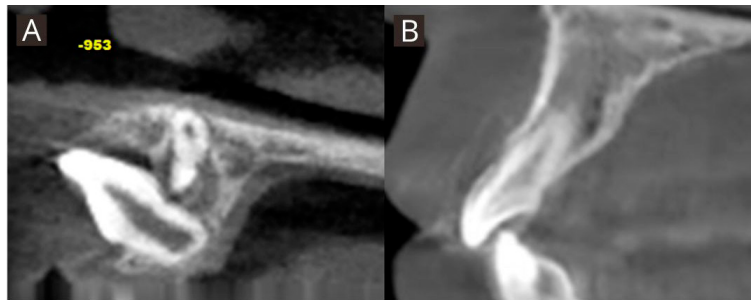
Tomographic images. A. Initial evaluation of tooth 21 in CBCT, sagittal section. B. Final evaluation of tooth 21 in CBCT, sagittal section.
